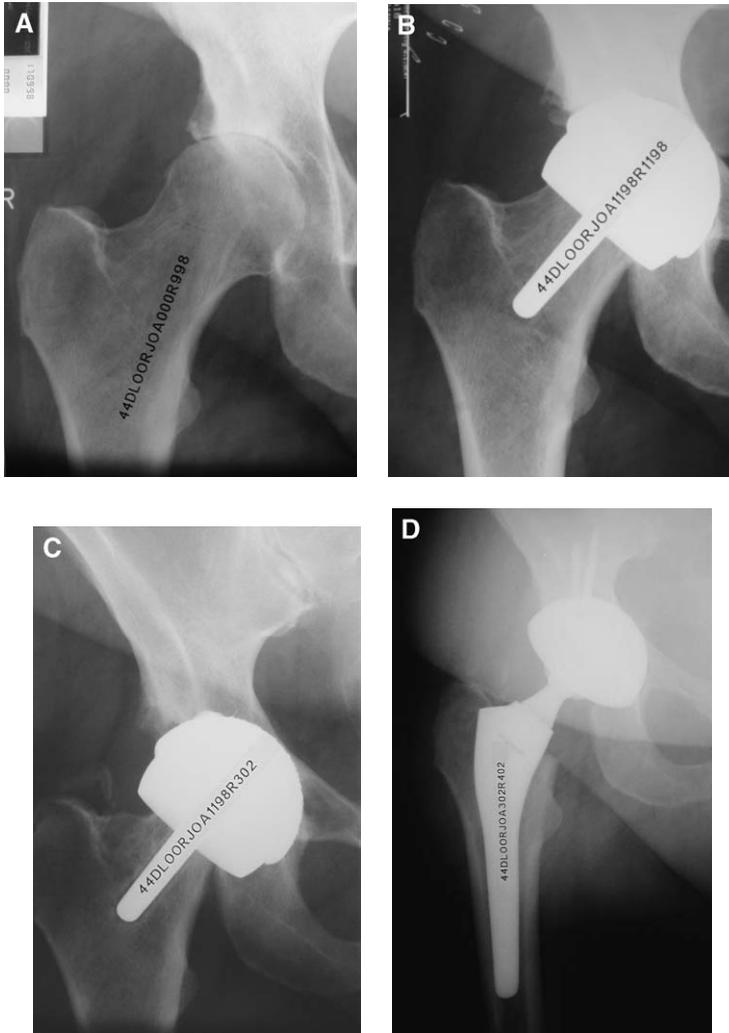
Radiographs showing low-grade infection. In addition to osteolysis in all cup zones and the femoral neck, an osteolytic line is seen in the three zones around the stem. (A) Preoperative. (B) Immediate postoperative. (C) Four years postoperative. (D) Revision.
